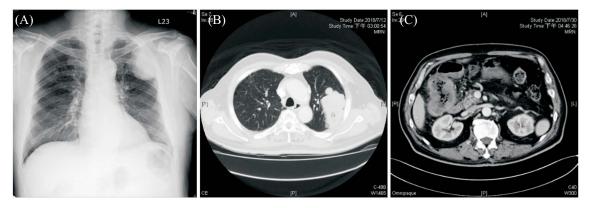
(A) Chest radiography revealed a lung mass in the left upper lobe. (B) Chest computed tomography revealed an 8-cm nodule in the left upper lobe. (C) Abdominal computed tomography revealed an 8- × 2-cm tumor in the hepatic flexure colon with lymph node enlargement.
